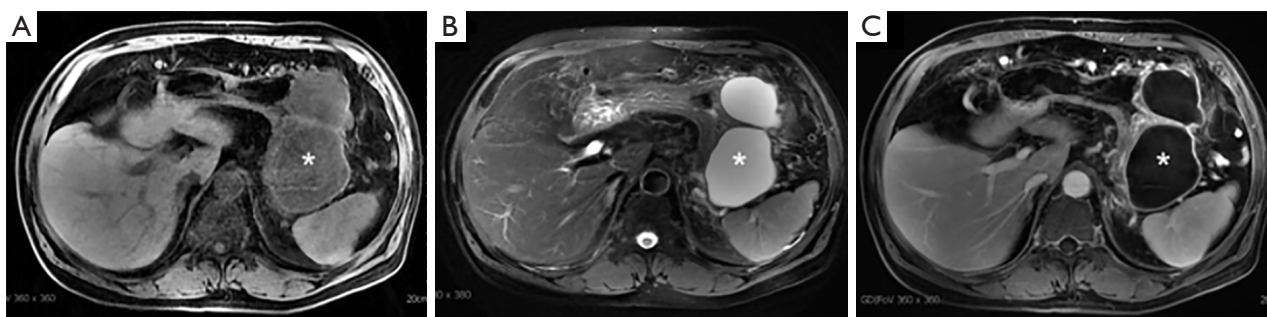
A 68-year-old man with acute pancreatitis 4 months after onset. Two peripancreatic encapsulated fluid collections (asterisk) show hypointensity on the T1-weighted image (A) and hyperintensity on T2-weighted image (B). After contrast injection, only the wall was enhanced (C, asterisk). Fine needle aspiration for the collections confirmed that they were pseudocysts.
